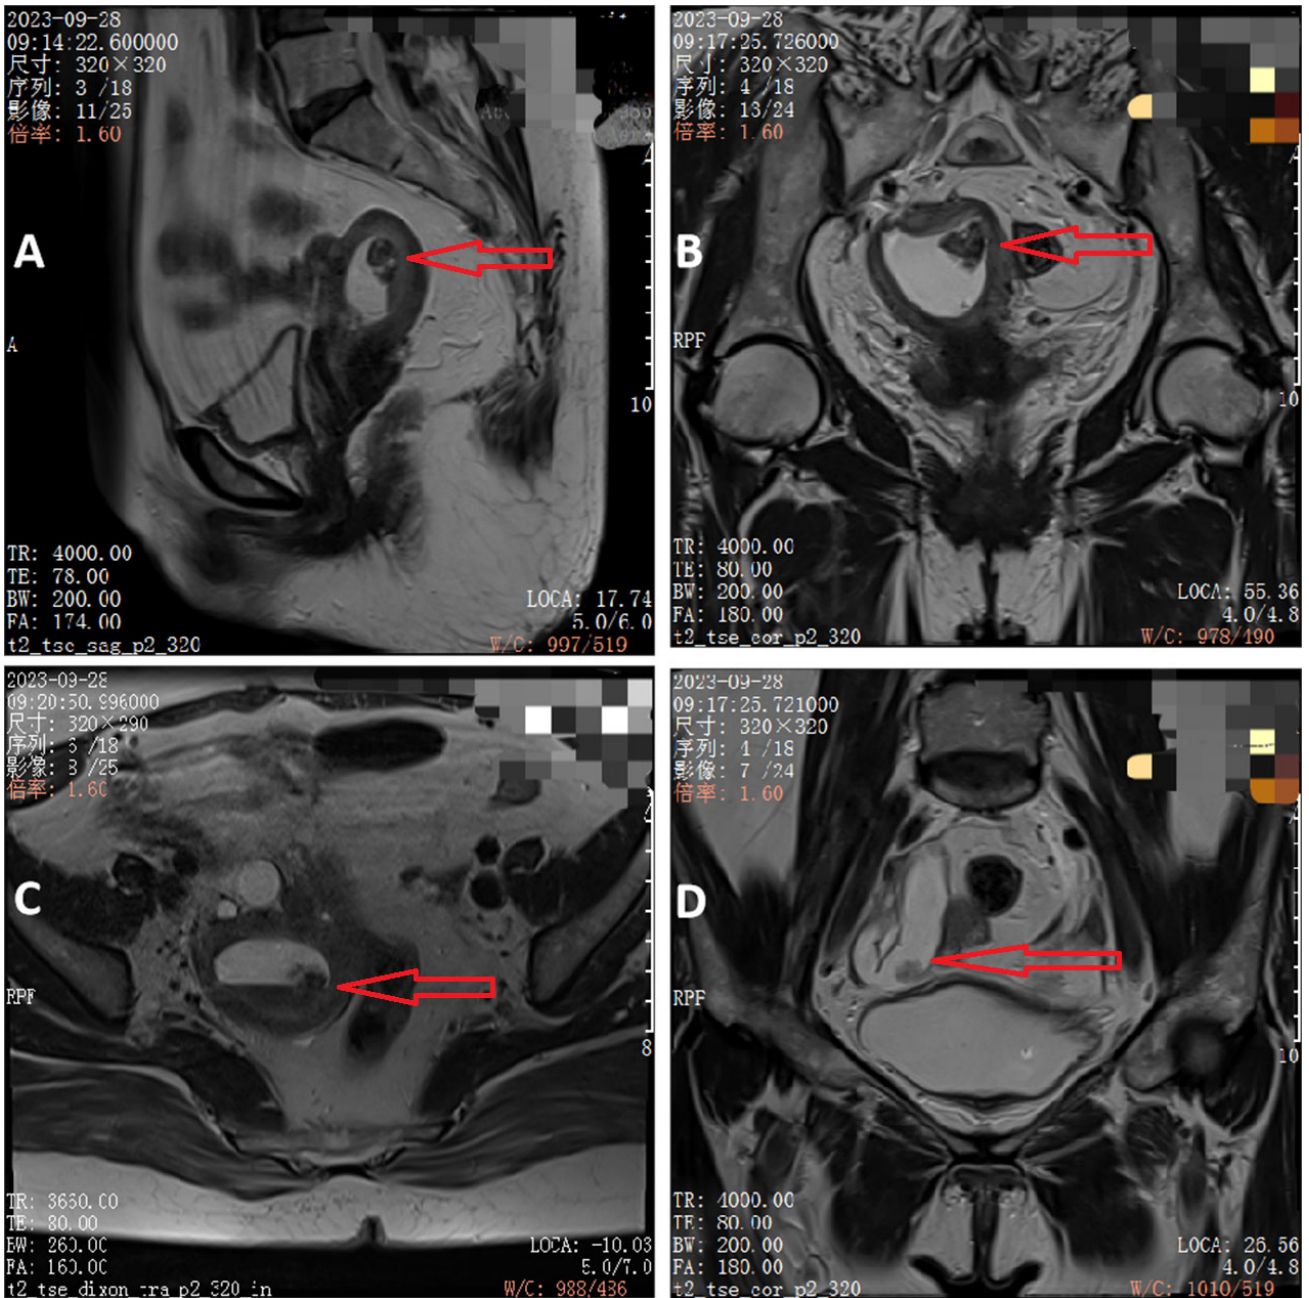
Pelvic enhanced magnetic resonance imaging (MRI) for the patient revealing uterine and right fallopian tube masses. (A–C) Uterine mass. (D) Right fallopian tube mass. The red arrow points to the uterus/right fallopian tube mass. RPF, Retroperitoneal Fibrosis; TR, Repetition Time; TE, Echo Time; BW, Blood Flow Width; FA, Fractional Anisotropy; LOCA, Location; W/C, Wall/Cavity.
